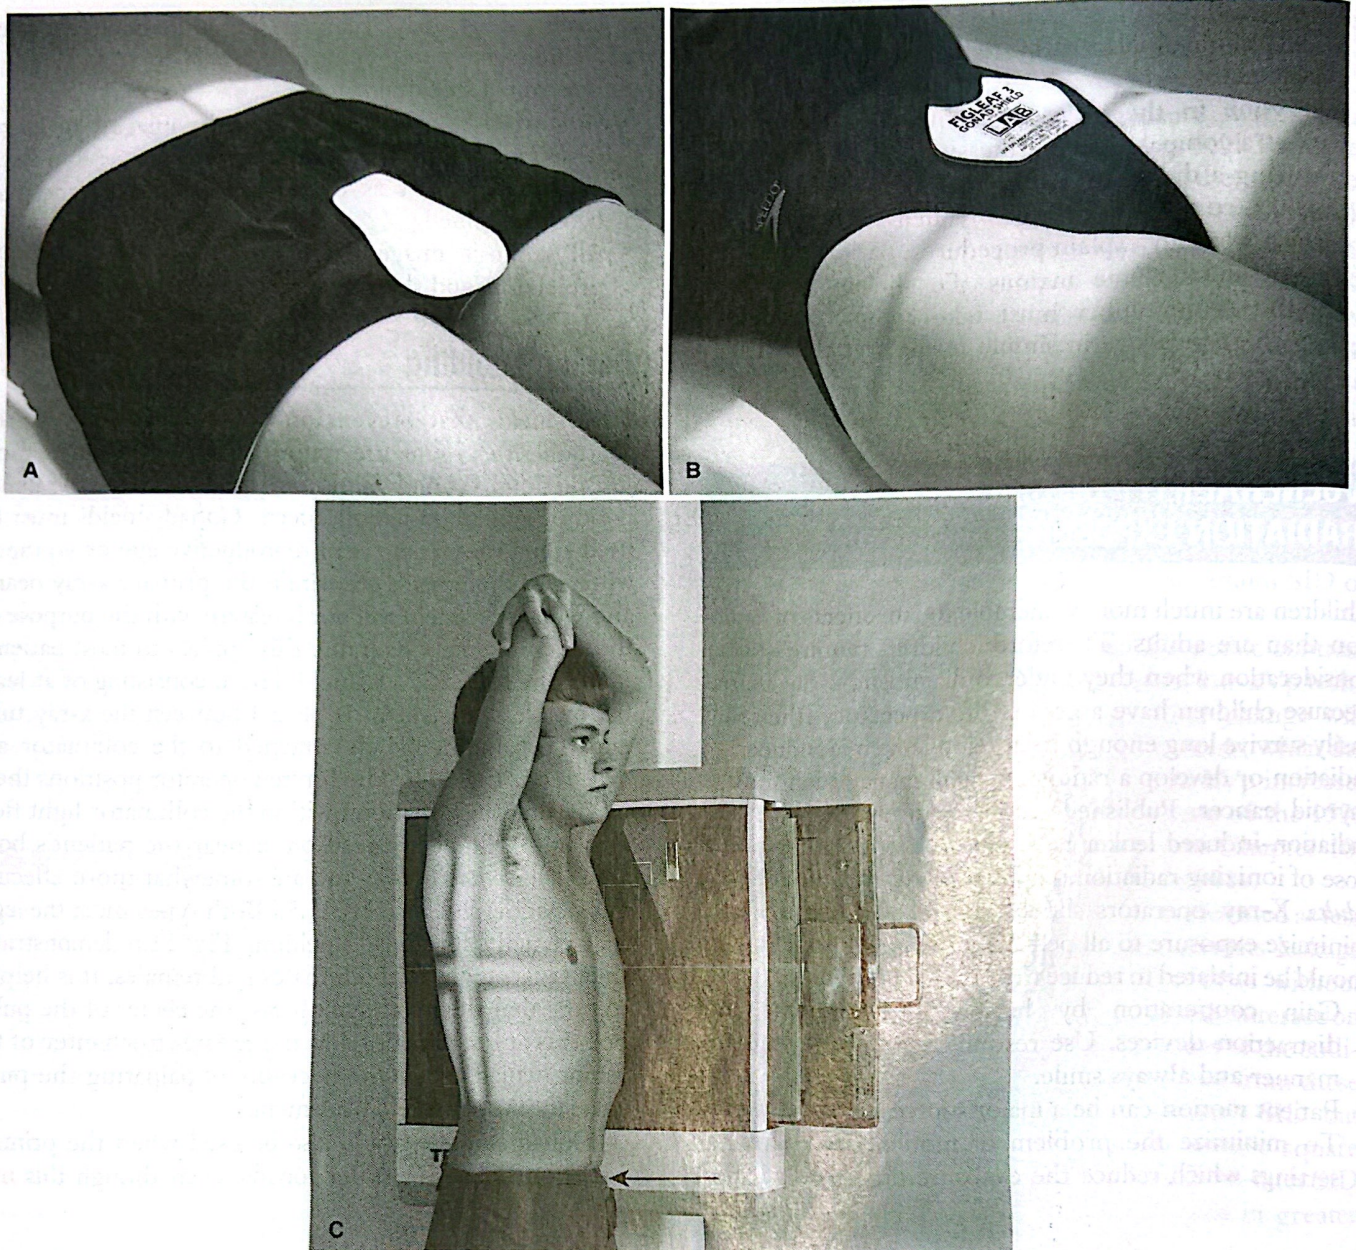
Contact shields are placed on the patient's body during exposure. (A) Male shielding. (B) Female shielding. (C) Wrap-around shield (*arrow*) is placed on the waist for a chest x-ray.
